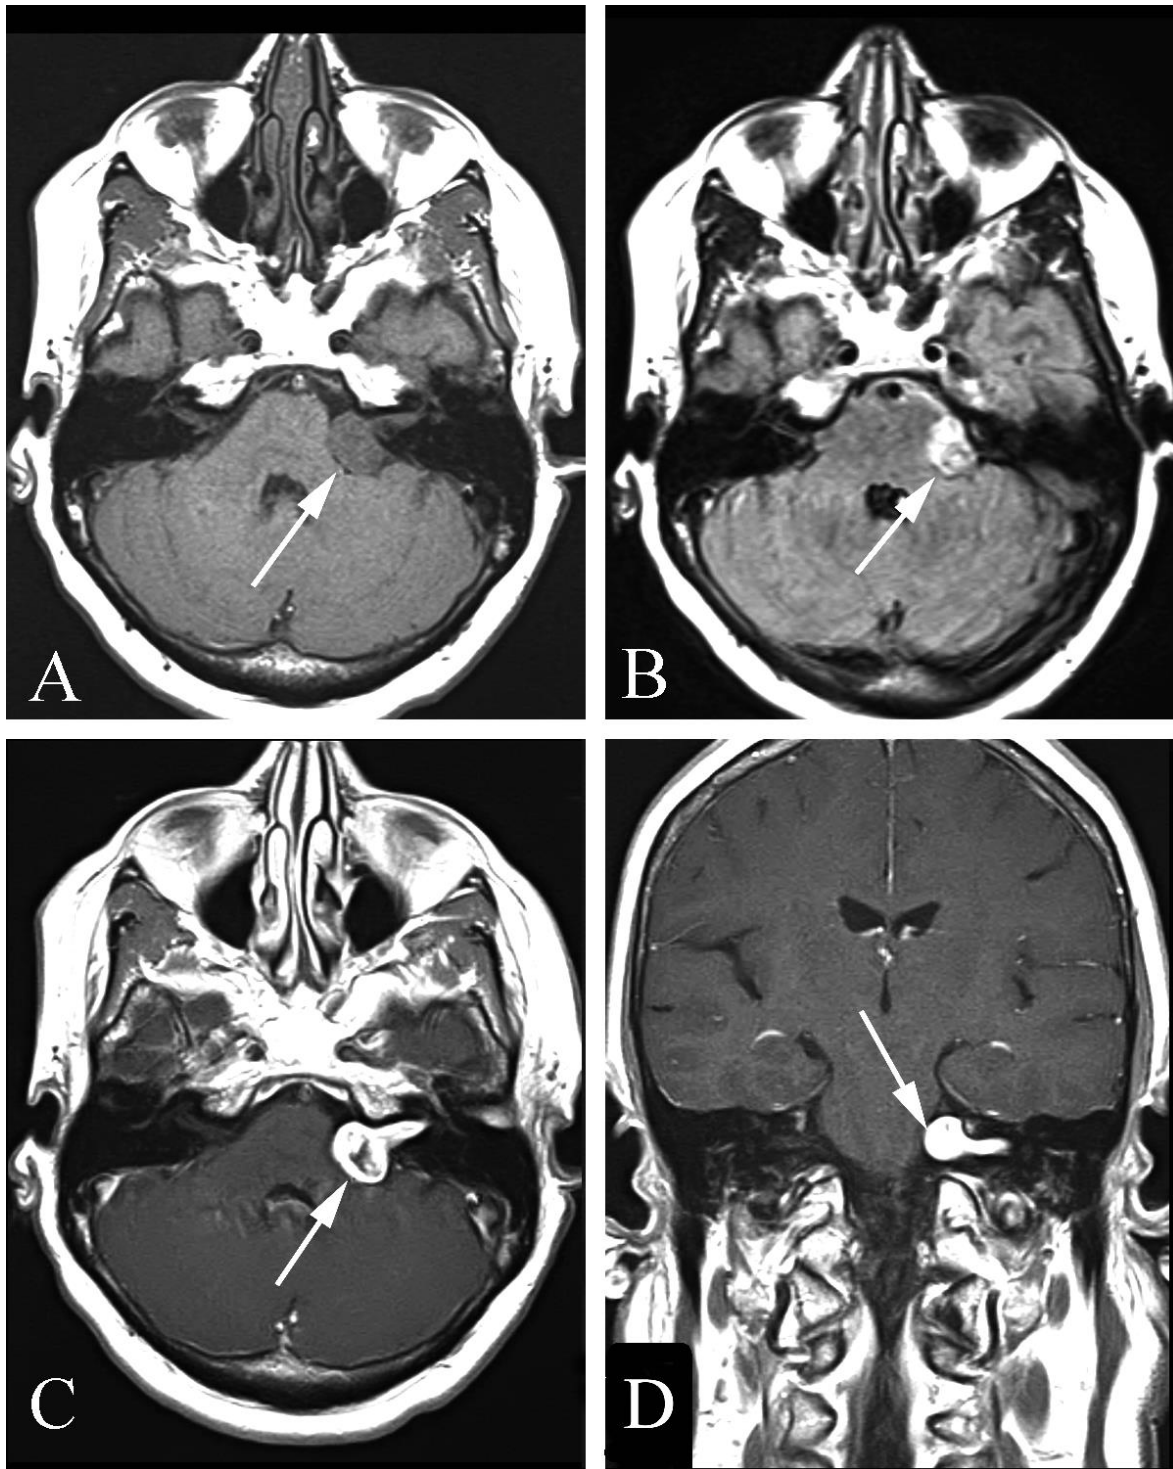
Vestibular schwannoma in a 55 year old woman with sensorineural hearing loss, tinnitus, and headache. A. Axial T1 weighted MR shows a cerebellopontine angle extra-axial lesion (arrow) which shows slightly decreased signal intensity relative to the adjacent brain. B. Axial FLAIR MR image demonstrates increased signal in the lesion (arrow) compared to the adjacent brain. C. Axial postcontrast T1 weighted image demonstrates the typical “ice-cream cone” appearance of the left vestibular schwannoma, with intense contrast enhancement particularly around the peripheral aspect of the tumor (arrow). D. Coronal postcontrast T1 weighted image also shows the “ice-cream cone” appearance and extension of abnormal contrast enhancement along the course of the vestibular-cochlear nerve in the internal auditory canal.
